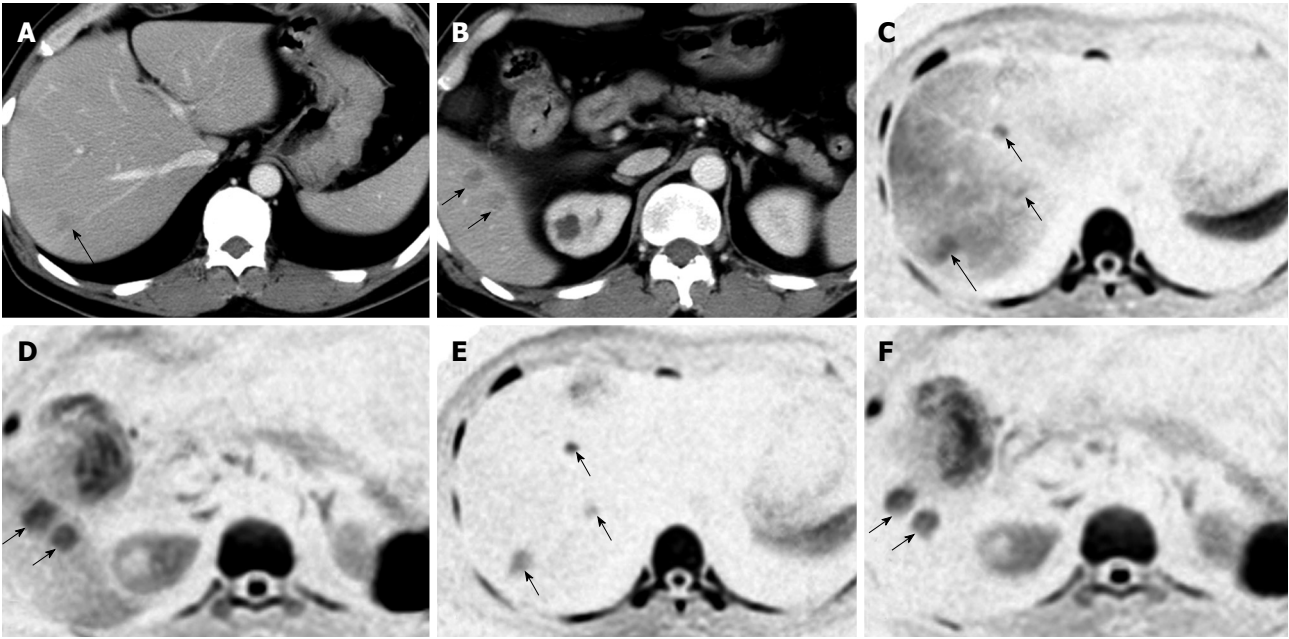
A case of hepatic metastases of colon cancer. A, B: Dynamic computed tomography of the liver in the portal phase showing multiple metastatic lesions, which are indicated as low-density masses (arrows); C, D: Diffusion-weighted imaging (DWI) of the same locations as in (A) and (B), clearly showing metastatic lesions as high signal intensities; E, F: After SPIO administration, the background signal intensity of the liver parenchyma was reduced and the signal intensities of the metastatic lesions were seen more clearly.
